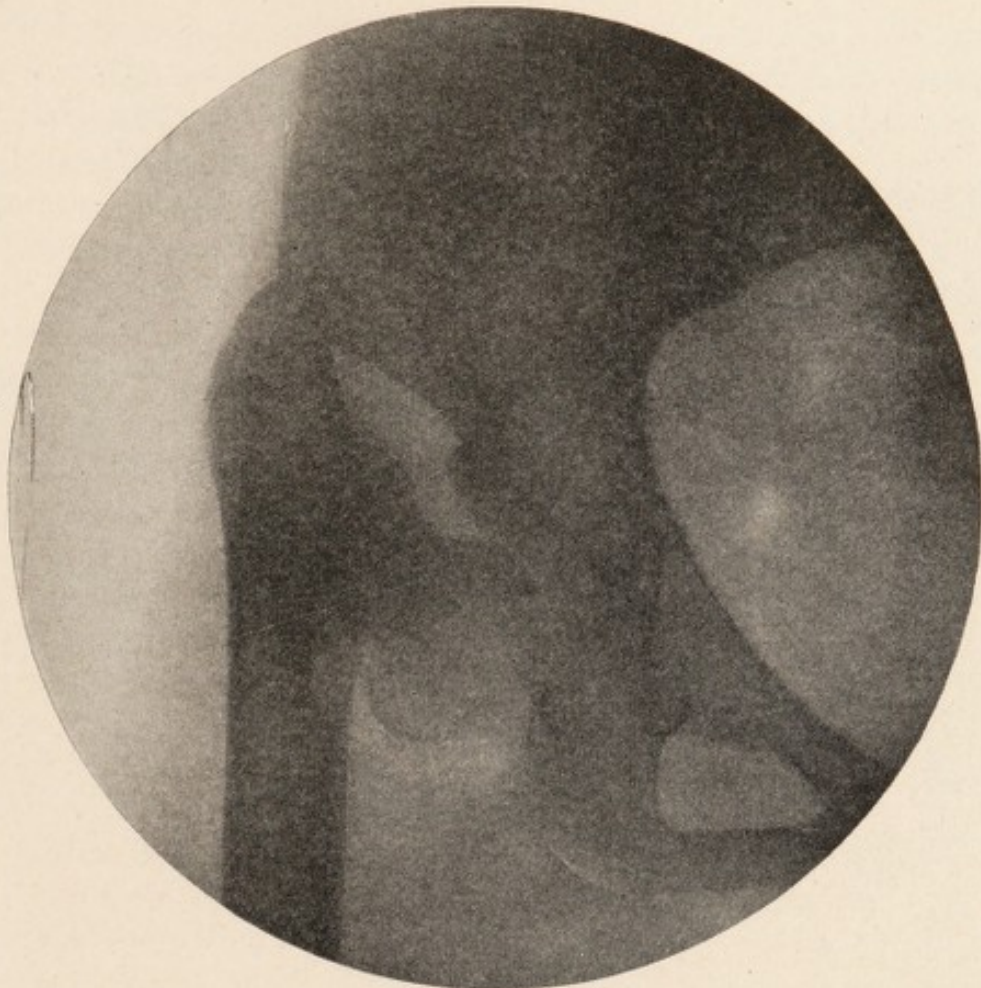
X-ray of same, left side. (*Robert Jones.*)
